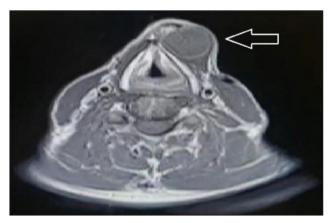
The preoperative contrast enhanced neck MR image of the patient.
